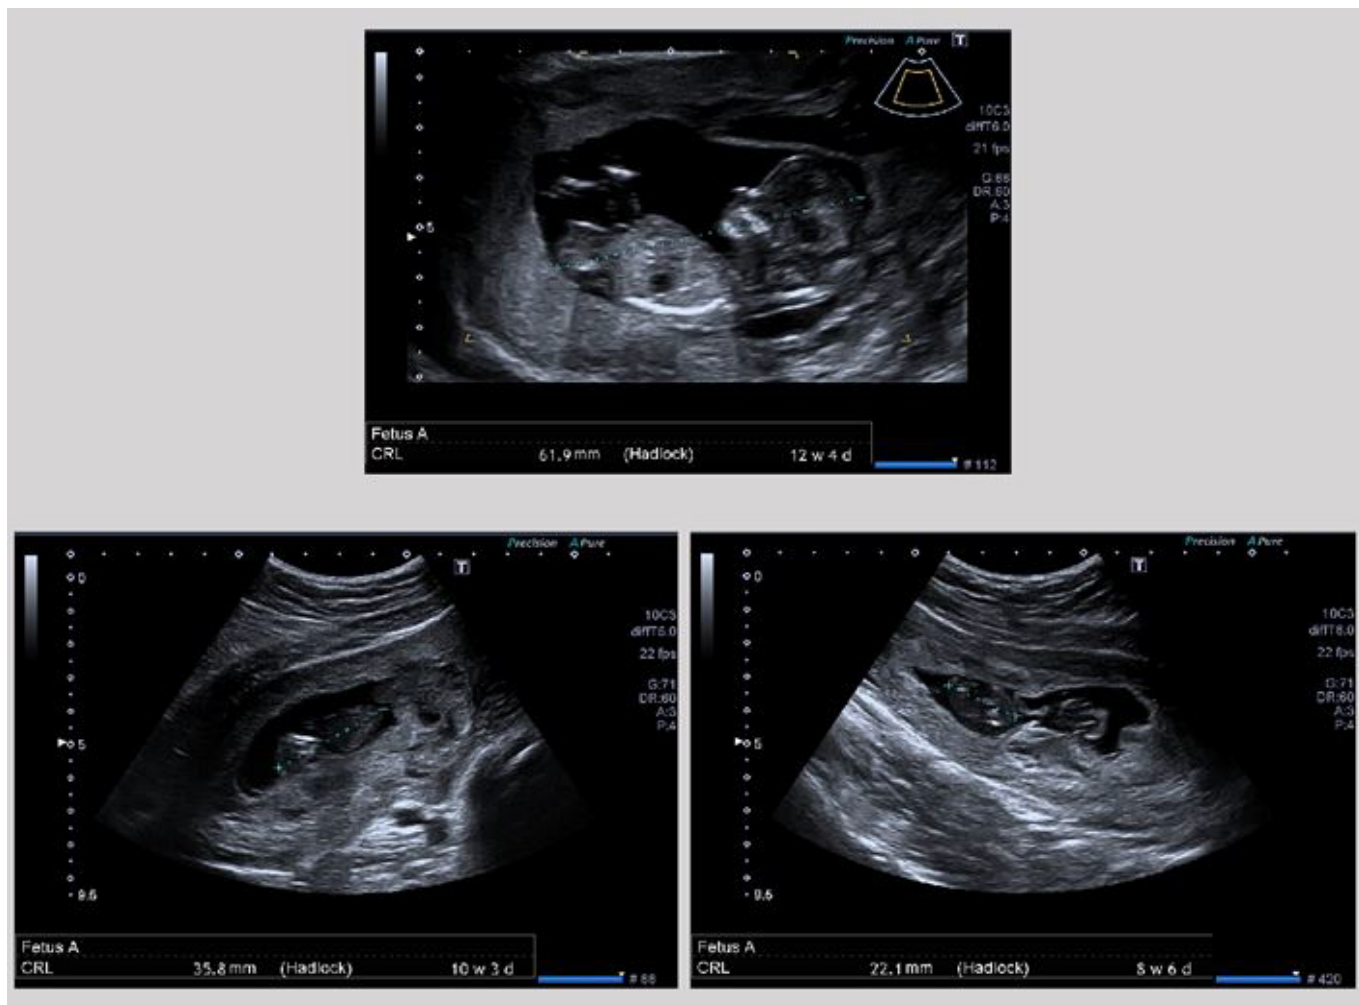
First trimester ultrasound demonstrated a single continuing viable intrauterine pregnancy with a CRL of 61.9 mm (Fetus A) and 2 missed miscarriages with a CRL static at 35.8 mm (Fetus B) and 22.1 mm (Fetus C) with absent fetal heart beat.
